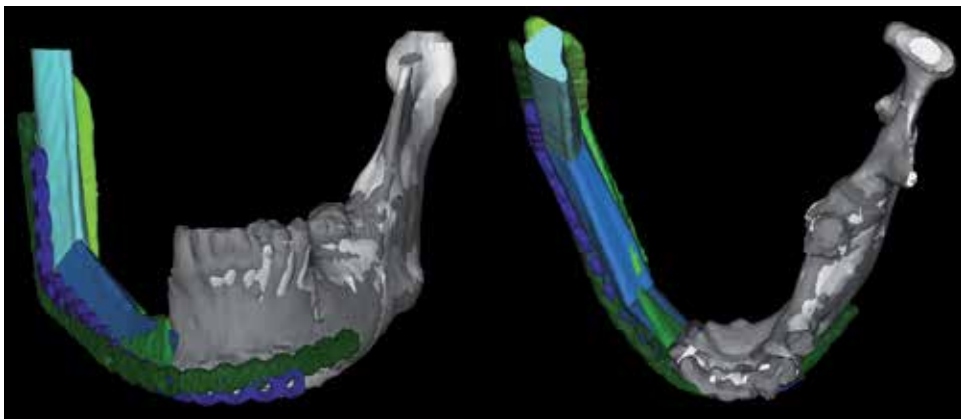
Overlay of the designed neomandible (blue segments) with the actual postoperative mandibular reconstruction (green segments) evaluated by 3D CT.
